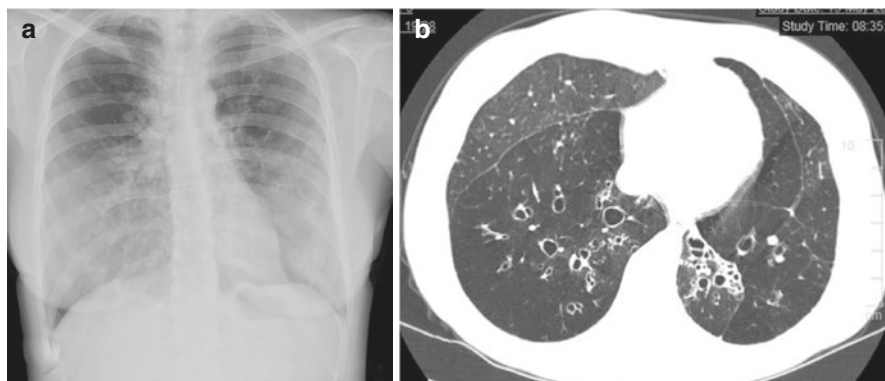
Chest X-ray revealed bilateral heterogeneous opacities
